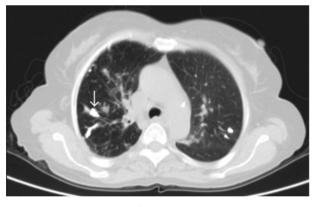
Axial section of CT Thorax showing tubular and branching calcified nodules (white arrow) within the bronchioles, in the upper lobe of both lungs.
